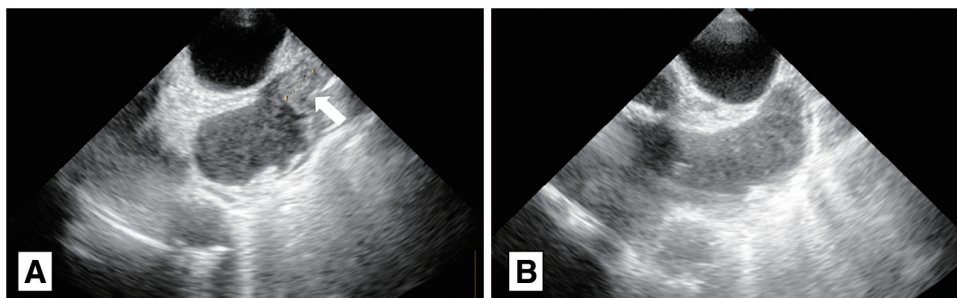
Postoperative findings in the imaging studies. (A) On day 1, echocardiography revealed a 17-mm thrombus in the left atrial appendage (white arrow). (B) After MT, the thrombus in the left atrial appendage had disappeared on day 7. MT: mechanical thrombectomy
